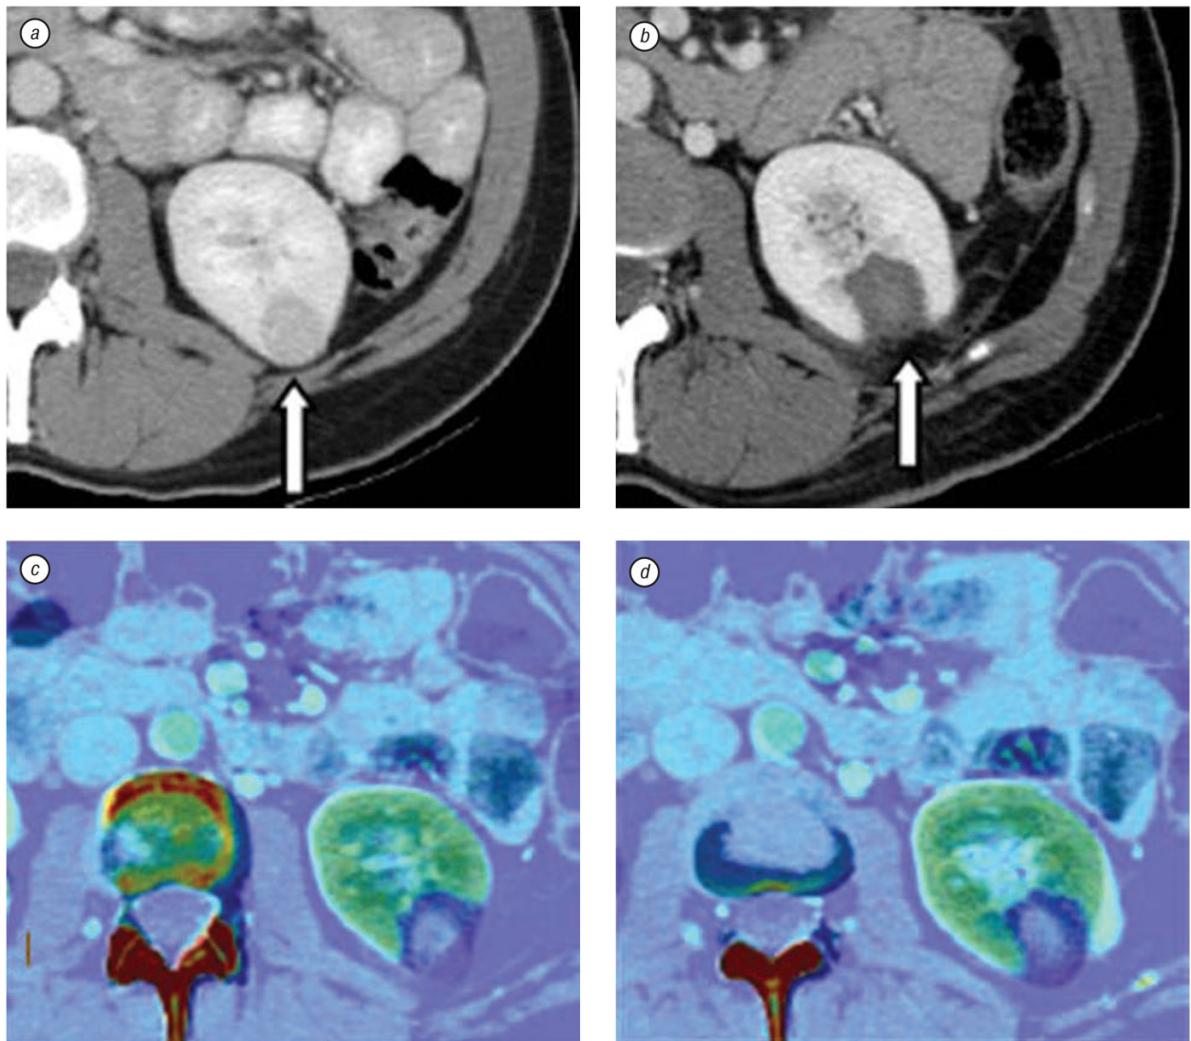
CT scan and elastic fusion images of kidney tumor and post-RFA thermal lesion. Contrast enhanced axial CT slices show a left kidney lesion before RFA (*a*, arrow) and thermal lesion two months after RFA (*b*, arrow). Due to change in kidney shape post ablation, elastic registration method is used to fuse pre- and post-RFA images (*c* and *d*), which defines treatment margins (dark blue)
